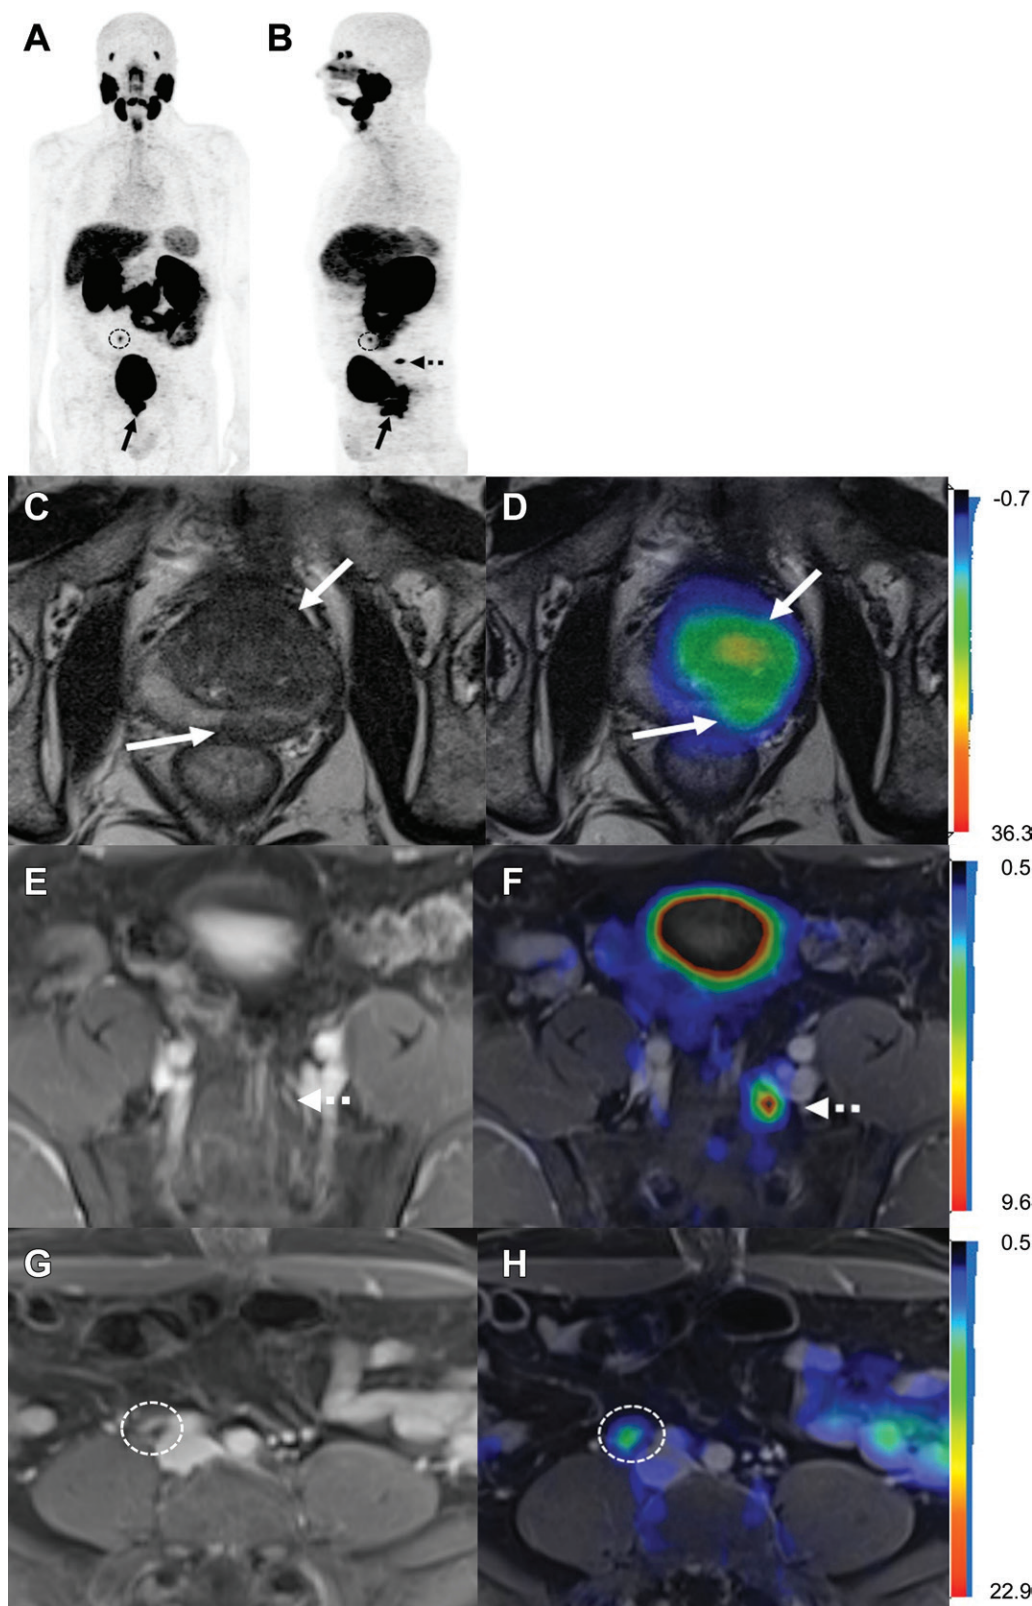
Images show 2-(3-[1-carboxy-5-[(6-[^{18}F] fluoro-pyridine 3-carbonyl)-amino]-pentyl]-ureido)-pentanedioic acid (^{18}F -DCFPyL) PET/MRI in a 68-year-old man with clinical T3 stage prostate cancer, International Society of Urological Pathology grade 5, with initial serum prostate-specific antigen level of 41 ng/mL. Conventional imaging (bone scan and CT; not shown) in this participant was negative for nodal or distant metastases. (A, B) Anteroposterior and lateral maximum intensity projection PET images show prostate-specific membrane antigen (PSMA)-avid primary tumor (solid arrows), pelvic nodal metastasis (dotted arrow), and common iliac nodal metastasis (circles). (C) Axial T2-weighted MRI scans in the prostate and (D) corresponding fused ^{18}F -DCFPyL PET/MRI in the prostate show extensive PSMA-avid primary tumor involving the transition zone and left peripheral zone of the gland (solid arrows). (E) Axial T1-weighted postgadolinium MRI and (F) corresponding fused ^{18}F -DCFPyL PET/MRI in pelvis show a small PSMA-avid left presacral lymph node (N1; dotted arrows). (G) Axial T1-weighted postgadolinium MRI and (H) corresponding fused ^{18}F -DCFPyL PET/MRI below the aortic bifurcation show a small PSMA-avid right common iliac lymph node (M1a; dotted circles). Planned local-regional treatment before the participant underwent PET was changed after undergoing PET to systemic therapy with androgen deprivation therapy.
